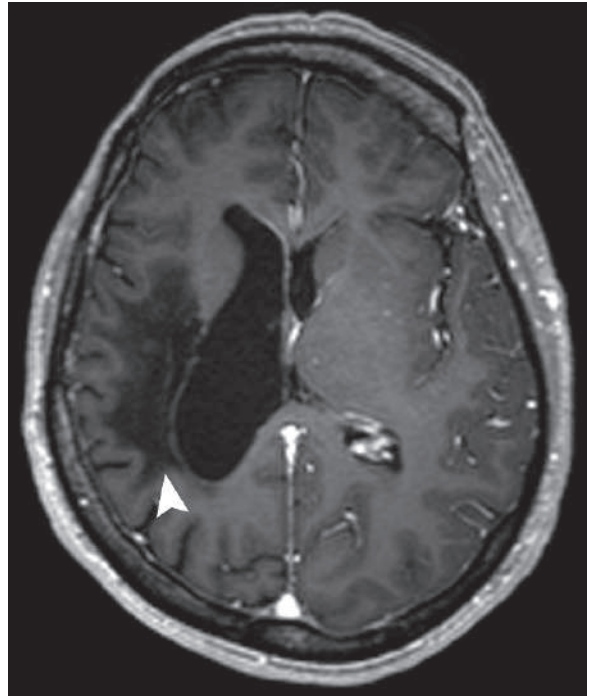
Axial T1W postcontrast MRI of a patient with previous brain infarction shows area (*arrowhead*) of hypointensity, with dilatation of the right occipital horn of the lateral ventricle adjacent to it (gliosis)
